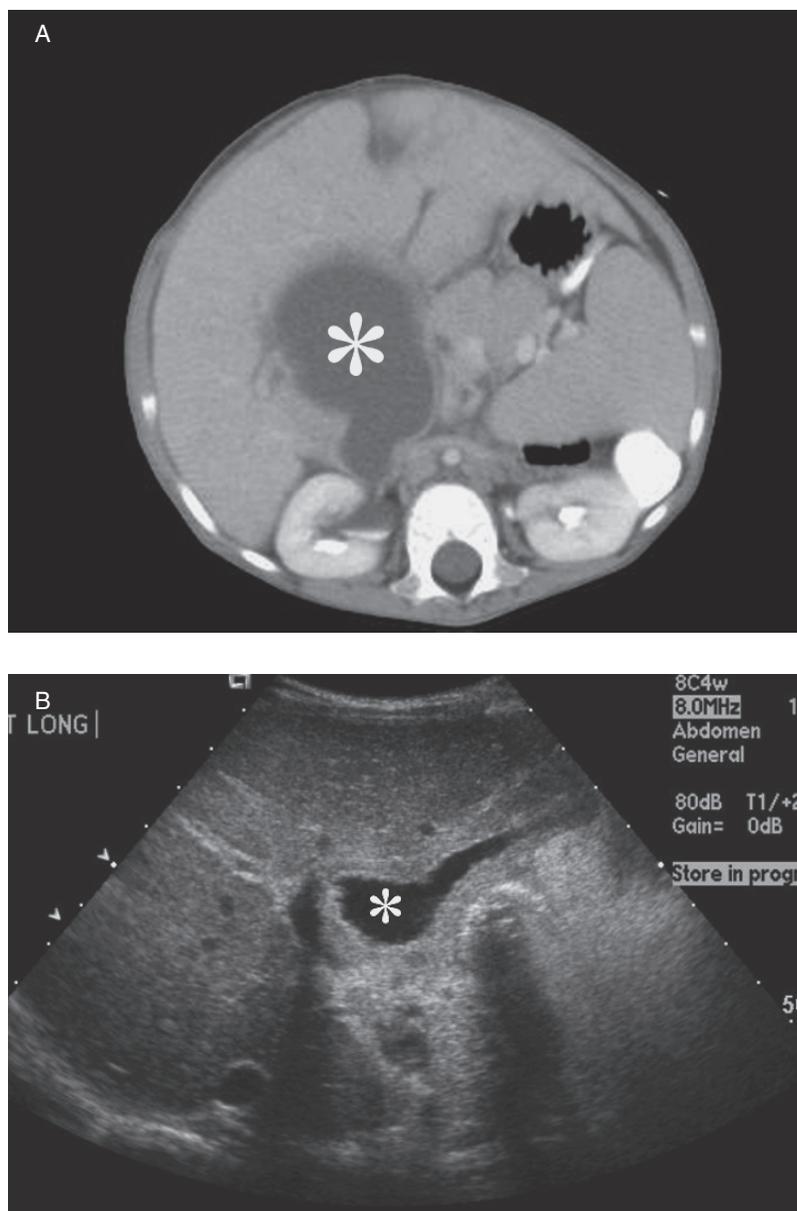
This patient had fever after cholecystectomy. (A) CT scan showing an abnormal fluid collection in the gallbladder fossa consistent with a biloma (*). (B) The fluid collection (*) on ultrasound which will guide drainage. (C) A drain in the biloma (*). Injection of the biloma shows filling of the intrahepatic bile ducts (arrows).
